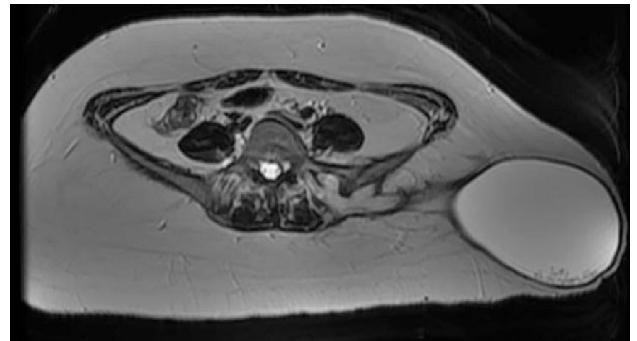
(b): MRI axial T2WI, showing fluid collection with hypointense rim. Ramified tract with its internal communication is much better shown on this sequence.
